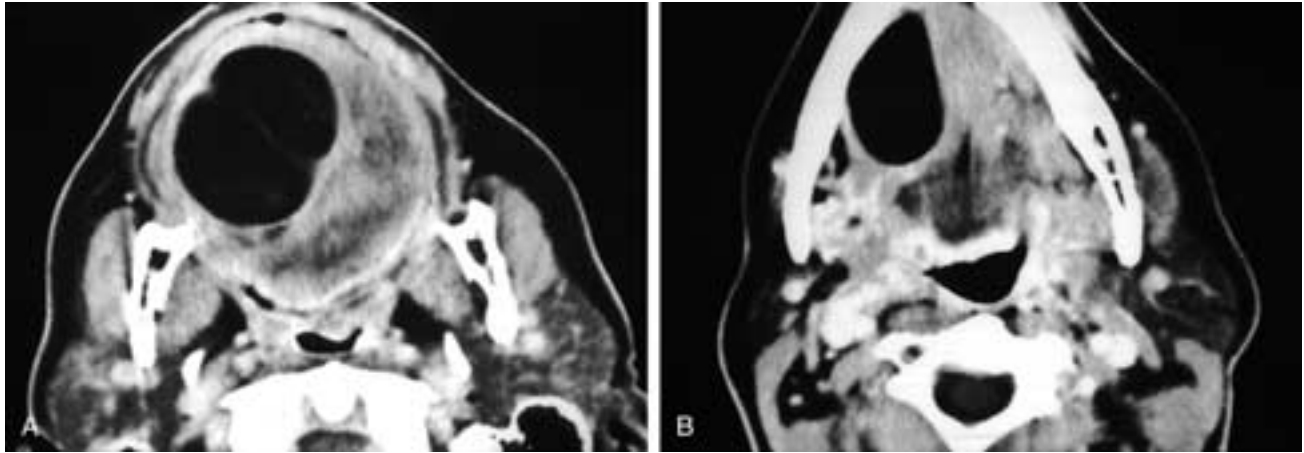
Axial contrast-enhanced CT scans through the tongue (A) and the floor of the mouth (B) show a well-delineated fat attenuation mass. This patient had a lipoma. Although dermoids may contain fat, they never consist predominantly of fat (compare this to [Fig. 35-41](#)).
